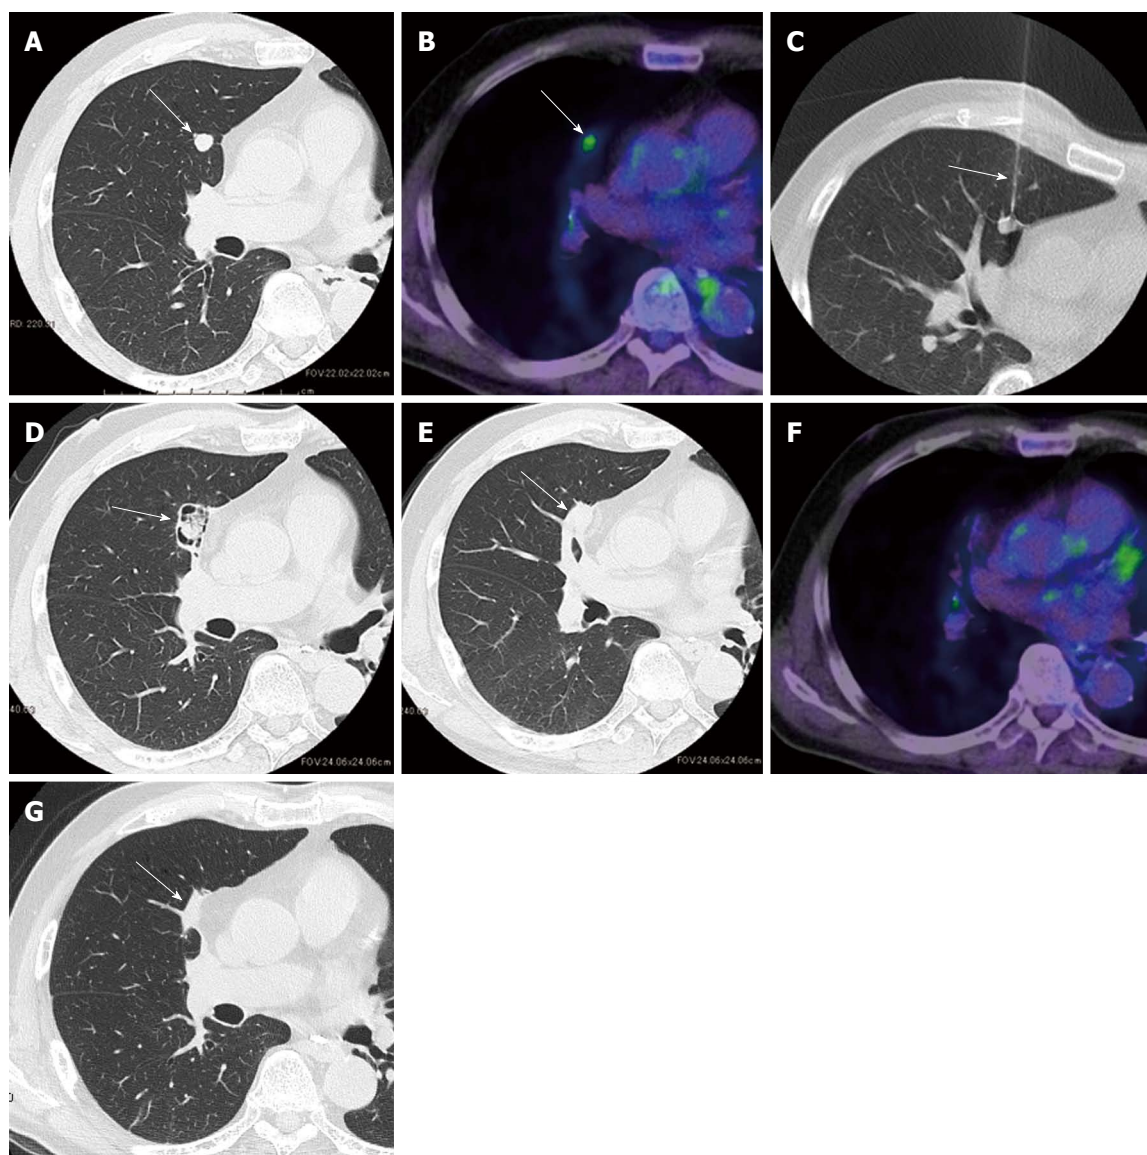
Pulmonary metastasis in a 68-year-old man with colorectal cancer treated with radiofrequency ablation. A: Computer tomography (CT) image before radiofrequency ablation (RFA) showing a tumor (arrow) 1.1 cm in size in the right middle lobe; B: Positron emission tomography (PET) image before RFA showing increased fluorodeoxyglucose (FDG) uptake by the tumor (arrow); C: CT fluoroscopic image obtained during RFA showing the treatment of the tumor with a multitined expandable electrode (arrow); D: CT image 1 mo after RFA showing cavity formation around the ablated tumor (arrow); E: CT image 3 mo after RFA showing cavity collapse and an increase in the size of the ablation zone (arrow) beyond the tumor size before RFA; F: PET image 6 mo after RFA showing the disappearance of FDG uptake; G: CT image 24 mo after RFA showing the shrinkage of the ablation zone (arrow) and its appearance as a focal atelectasis.
